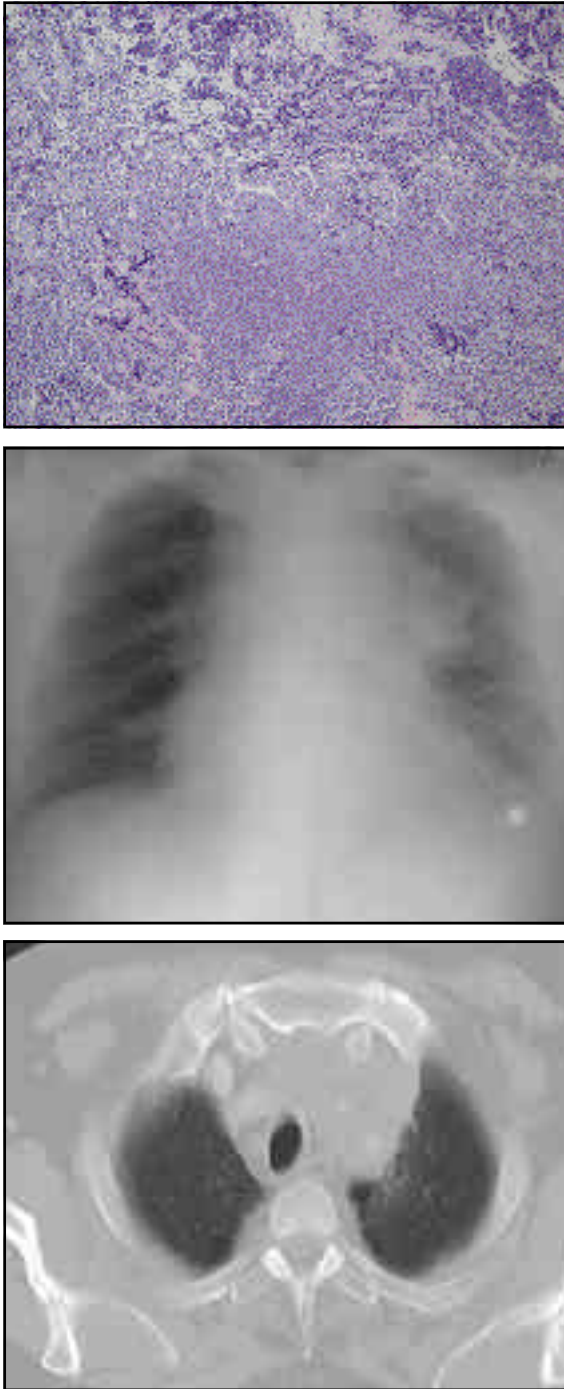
a-b. A lesion invading mediastinum in the superior lobe of the left lung in chest X-ray and thorax CT having the diagnosis of SCLC (July 2004), c. Mediastinotomy biopsy material revealed as small cell lung cancer, HE X 10
